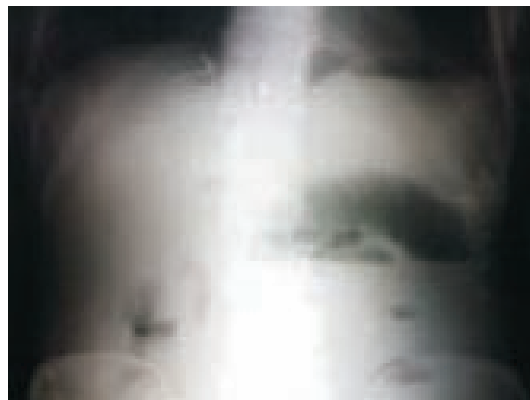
X-ray Abdomen Showing Multiple Air Fluid Level.
